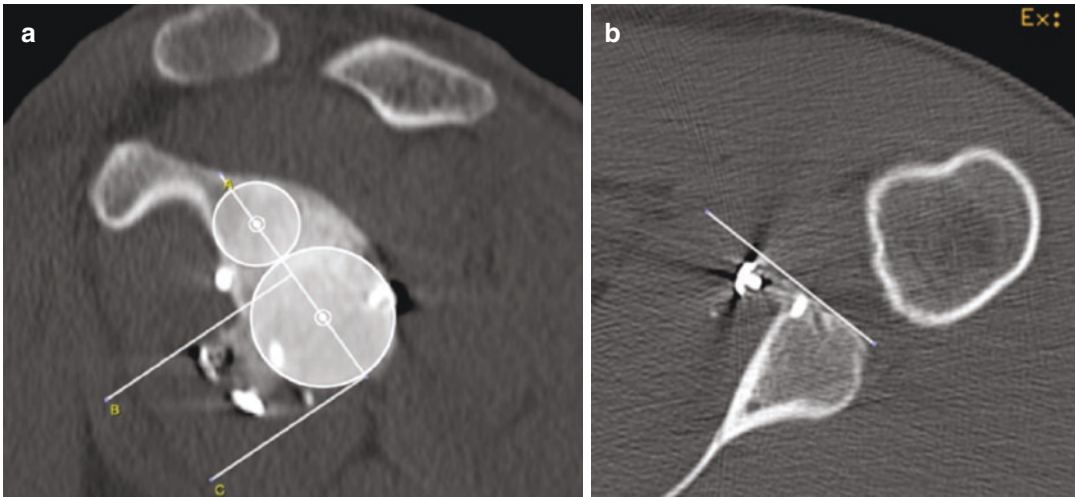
(a, b) CT scans at 1-year follow-up show bone graft healing and remodeling
